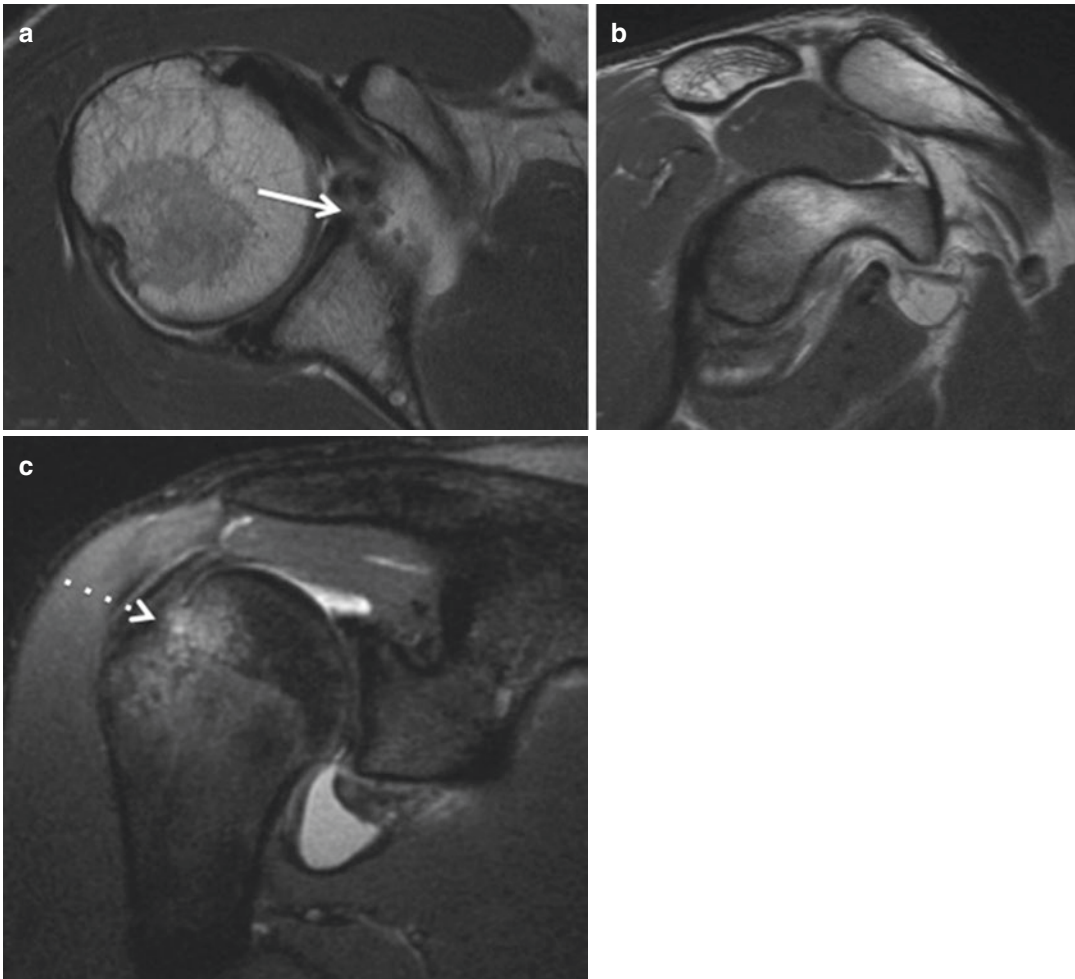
(a–c): Proton density axial (a) and sagittal (b) and inversion recovery coronal magnetic resonance images following the patient’s initial dislocation. There is significant fluid present in the joint. The axial (a) image demonstrates an antero-inferior labral tear (solid white
